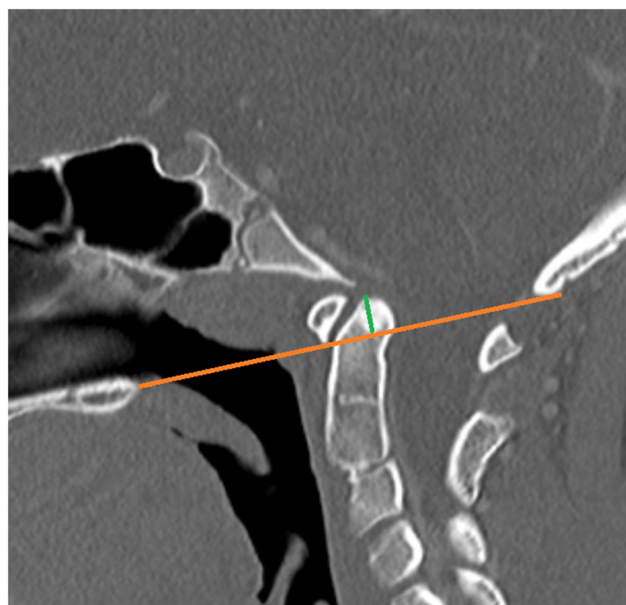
Basilar invagination as demonstrated by a sagittal reconstruction of a CT scan. The thin slice, isotropic acquisition, and the applied bone filter allow the excellent visualization of the bony structures and more precise measurements. The green line indicates that the tip of the odontoid process extends 6.6 mm above the McGregor line (brown)
